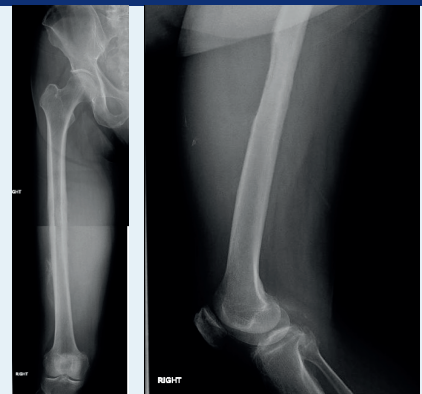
Pre-operative x-ray demonstrating perosteal reaction and anterior femoral cortical thinning.
